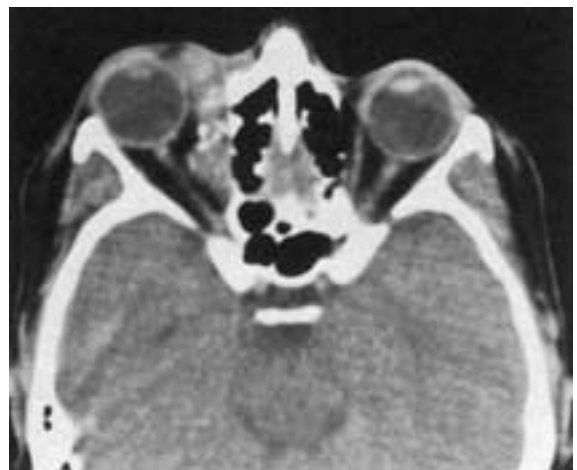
Amyloidosis of the right orbit with calcification. Axial CT section without infusion of contrast material reveals a mass in the extraconal space of the right orbit with a slight bulge into the intraconal space. Note the speckled calcifications within the amyloid deposit. The adjacent ethmoid sinus is normal. (From Weber AL, Mikulis DK. Inflammatory disorders of the paraorbital sinus and their complications. *Radiol Clin North Am* 1987;25:615–630.)
